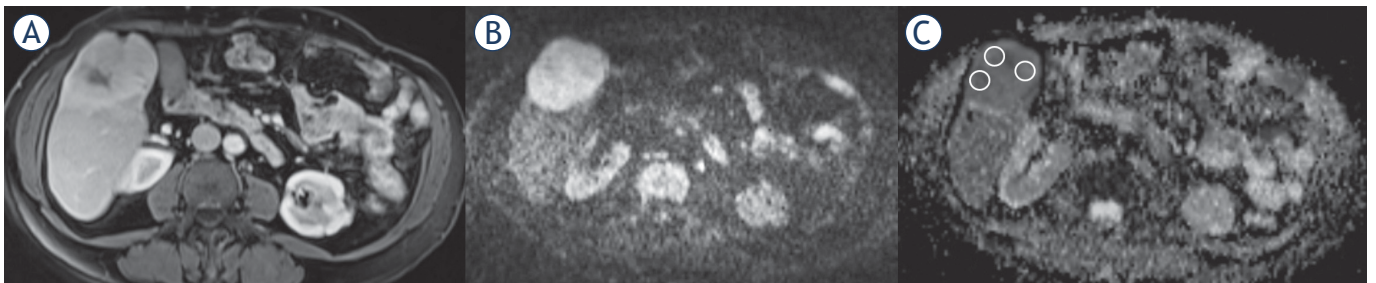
58-year-old female with an expansile liver mass with central hypovascular fibrous stroma and peripheral contrast enhancement on contrast-enhanced axial T1-weighted (T1W) (A) images, diffusion weighted image (DWI) obtained at b value of 800 s/mm² (B) and apparent diffusion coefficient (ADC) maps (C) with region of interests (ROI) placement with three different contrast enhancing area for calculating ADC_{mean} values.
